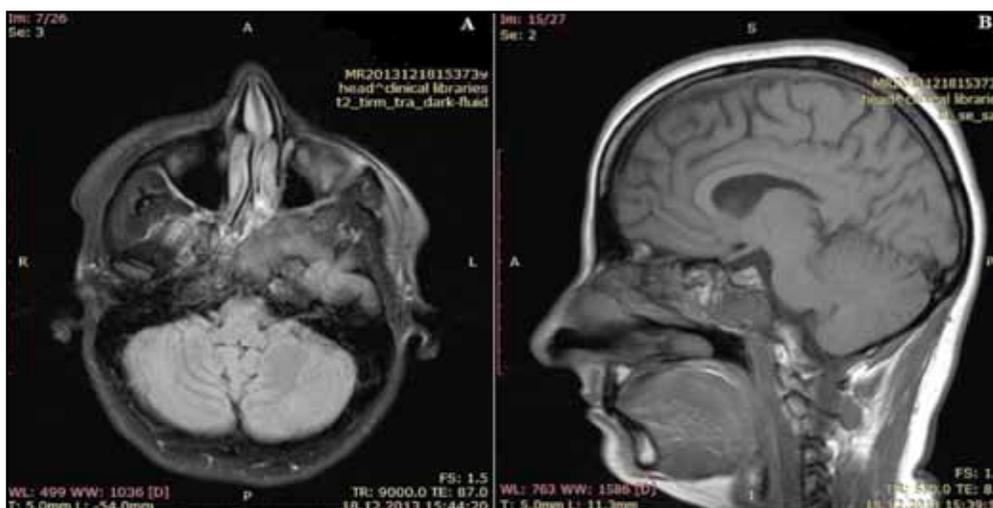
Contrast enhanced brain MRI – A. axial slice, T2-weighted image with high intensity signal showing an amorphous structure in the left half of the spongy bone of the sphenoid's body, the left greater wing and the base of the left pterygoid process; B. sagittal slice, T1-weighted image with low-intensity signal.
